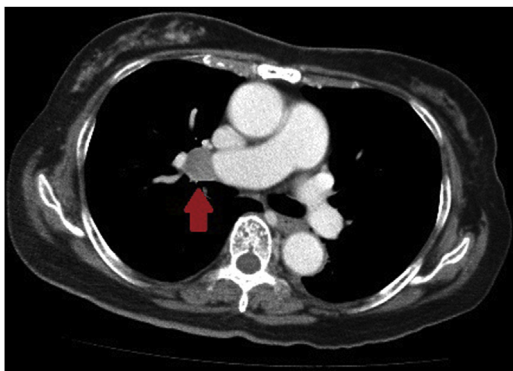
CT images of chest at initial diagnosis.
